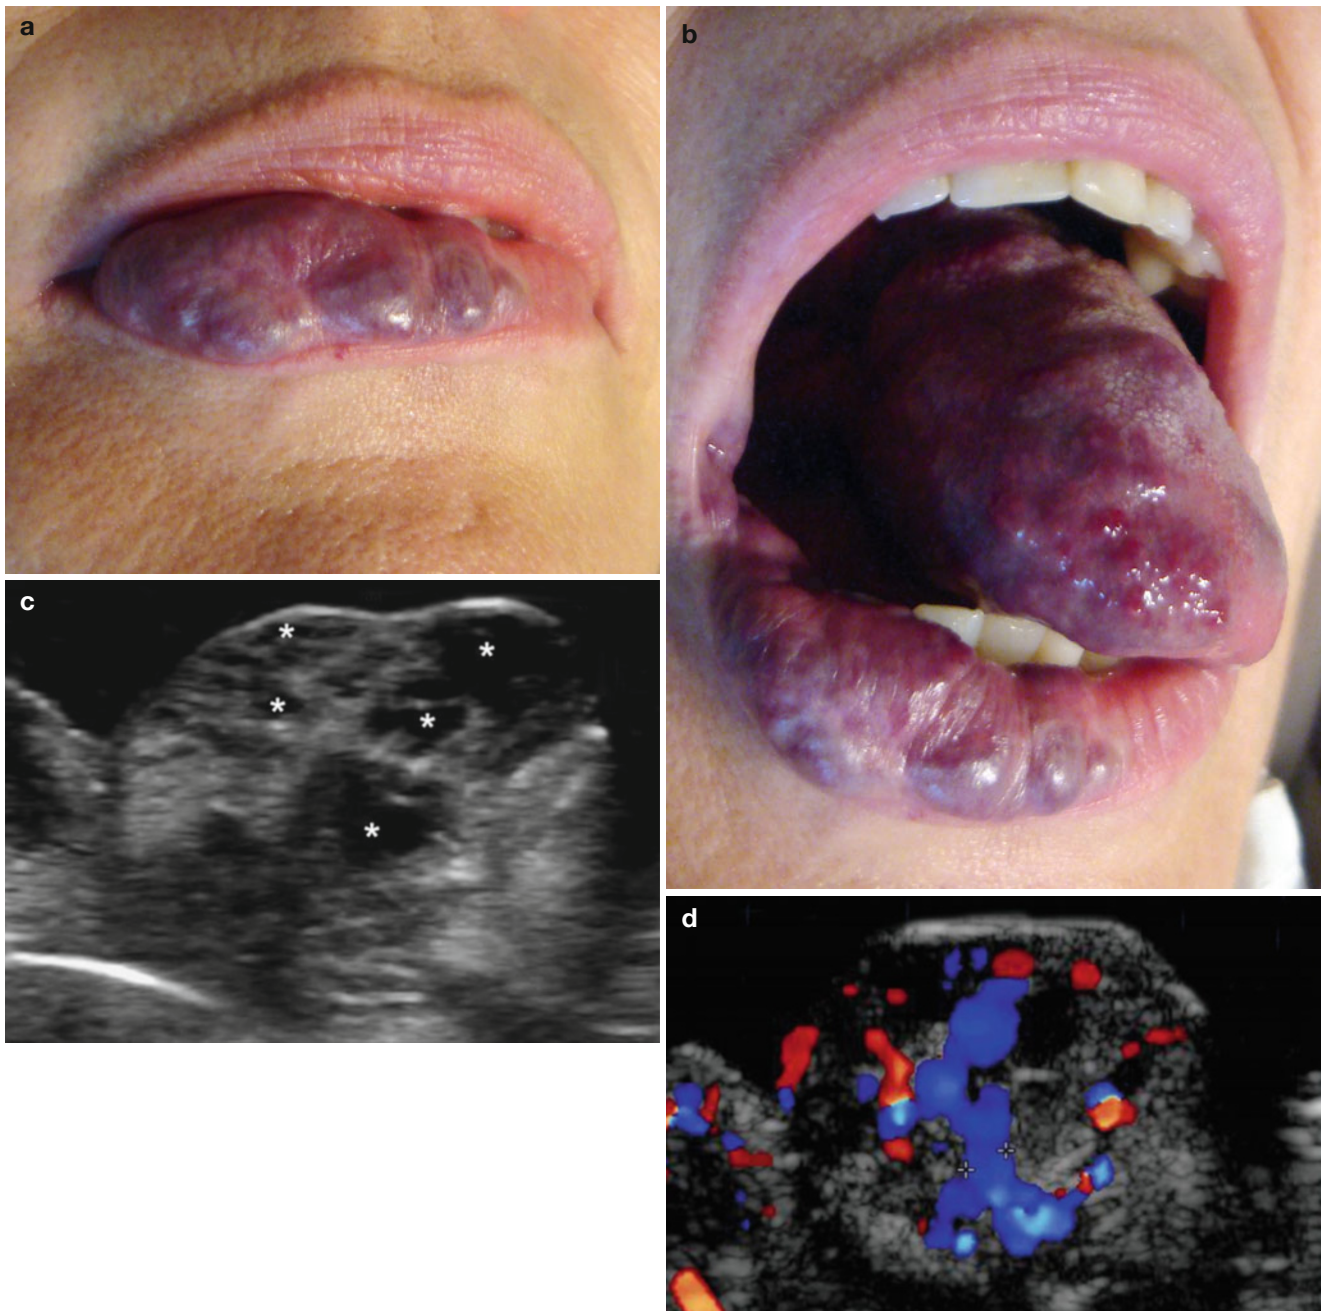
(a–g) Venous vascular malformation. (a, b) Clinical images of the lesions at the lower lip and tongue. (c) Ultrasound image (gray scale, longitudinal view) at the lower lip shows multiple anechoic tubular and pseudocystic structures affecting the dermis and the orbicular muscle of the lip. (d) Color Doppler ultrasound image demonstrates increased flow within the tubular and pseudocystic areas. (e) Color
